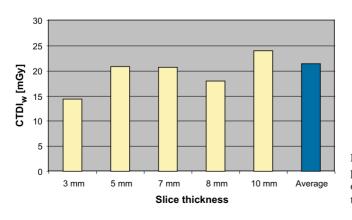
The patient dose (CTDI_w) applied by the participants of the German CT survey, 1999, for liver examinations was almost constant despite the selection of different slice thickness
